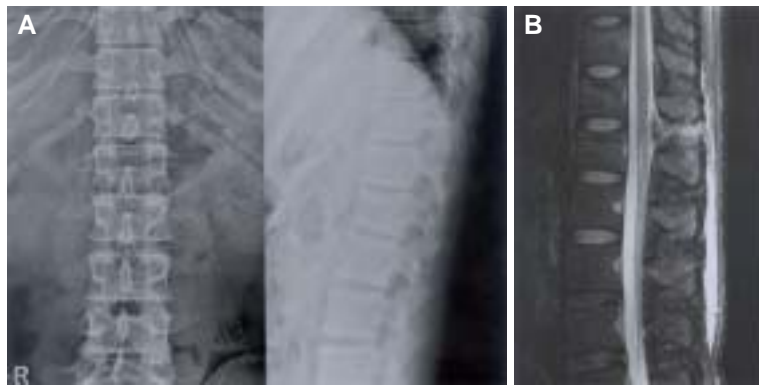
Radiography of a 36-year-old man shows compression fracture of vertebra body and separation of pedicle and transverse process of L1 (A). T2-weighted sagittal sequence of MR imaging shows disruption of supraspinatus and interspinous ligament (B).
